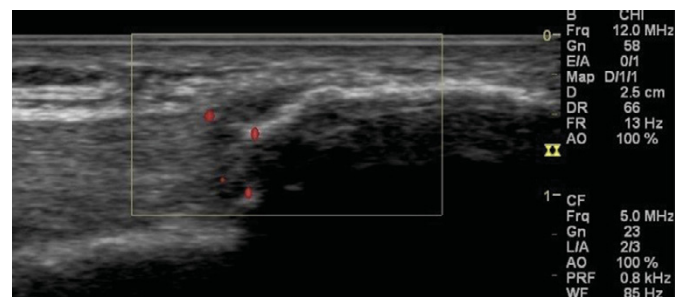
Ultrasonographic longitudinal scan of the tendoachillis showing hypoechoic area of edema & power Doppler signal at insertion.
